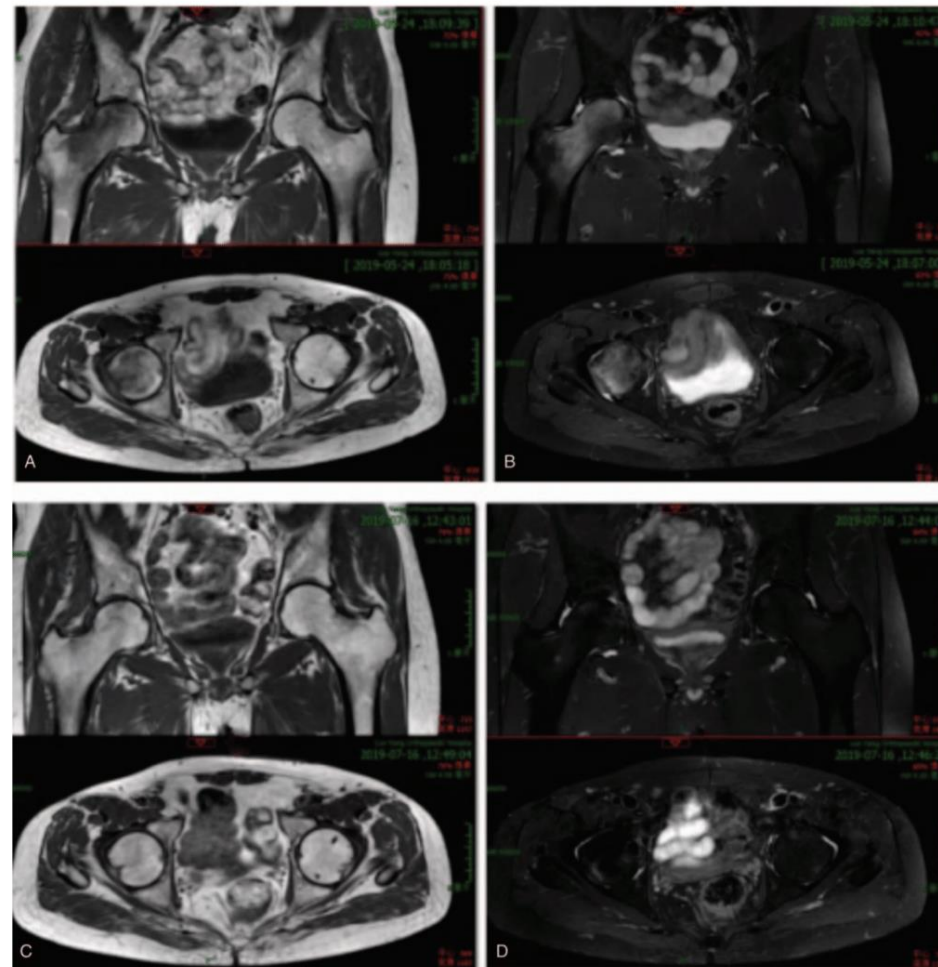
The pretherapy MRI (A,B) showing a large BME within the right hip. The MRI of 1.5 months posttreatment (C,D) showing reduction in the diffuse hyperintense signal of the femoral head and neck disappeared basically, and only a small amount of fluid remained in the hip joint cavity.
